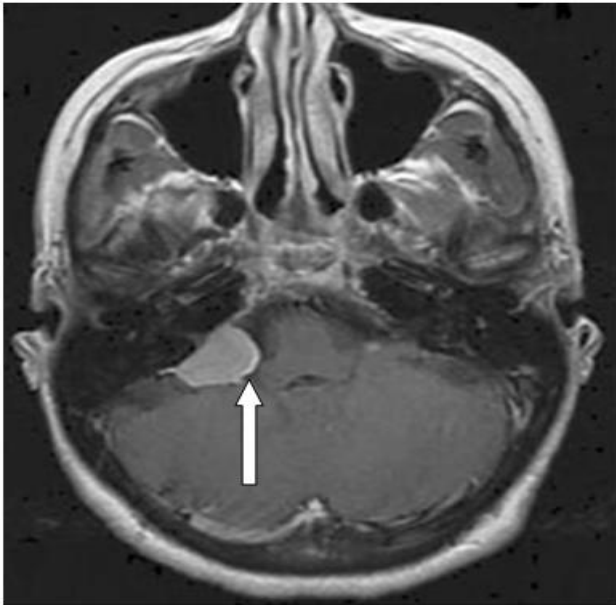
Axial post contrast MRI of brain with Rt cerebellopontine angle meningioma.
